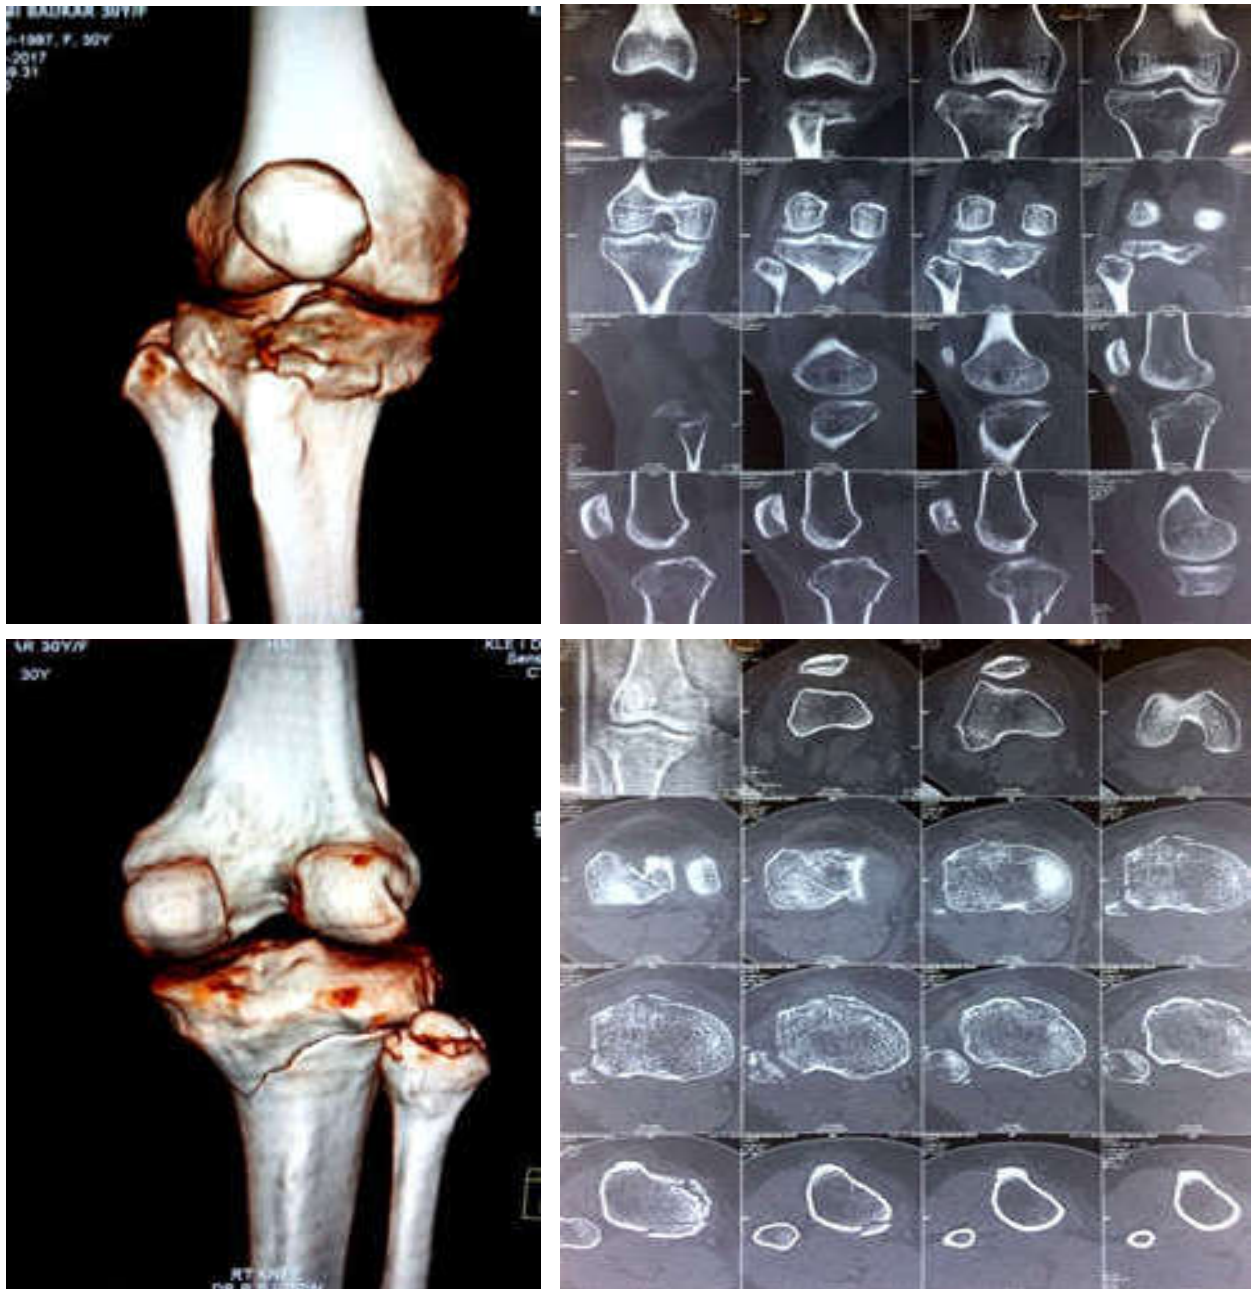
Pre-Operative CT Scan of Left Knee
